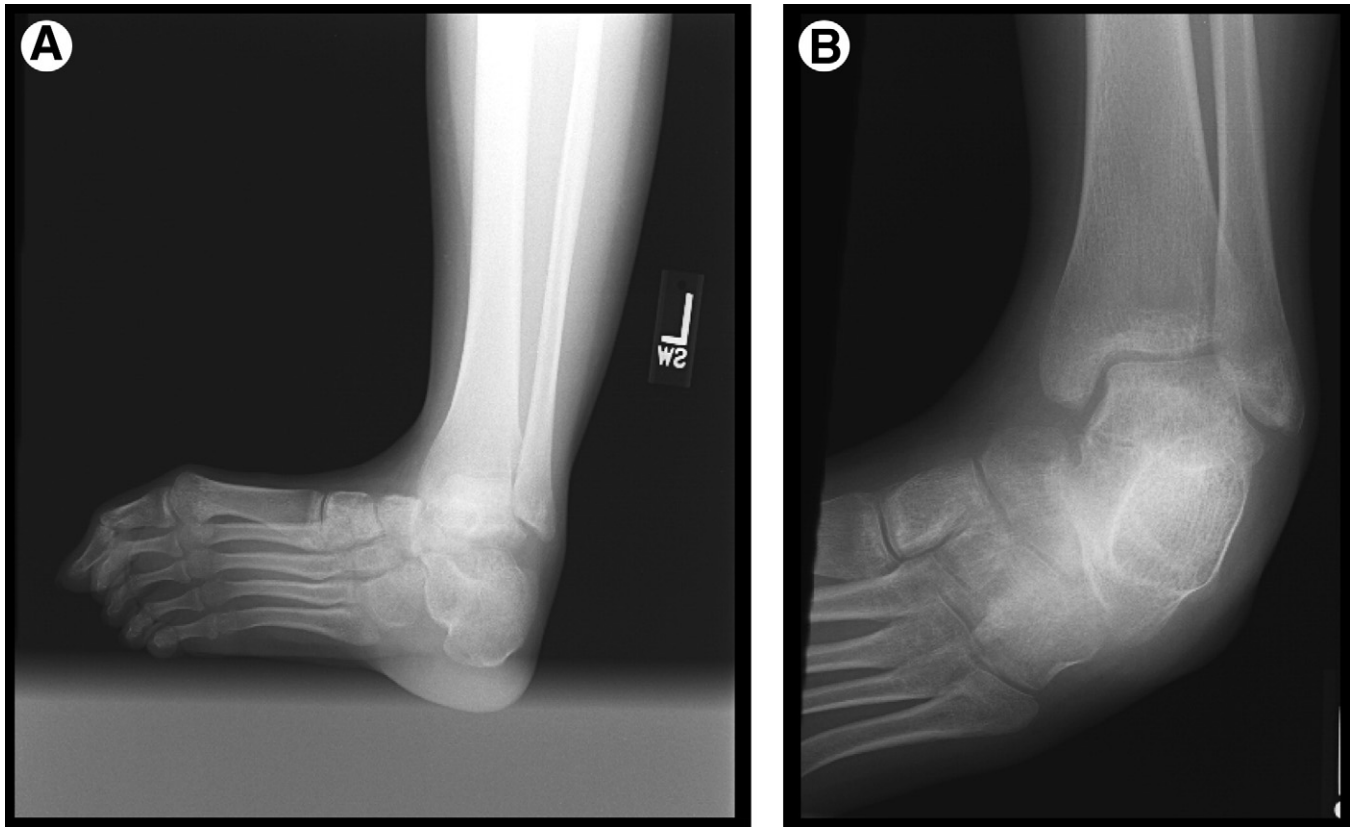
Radiographs of the left ankle demonstrate the severity of the deformity and multiple joints involved in the contracture. A. Anterior view. B. Mortise view.
